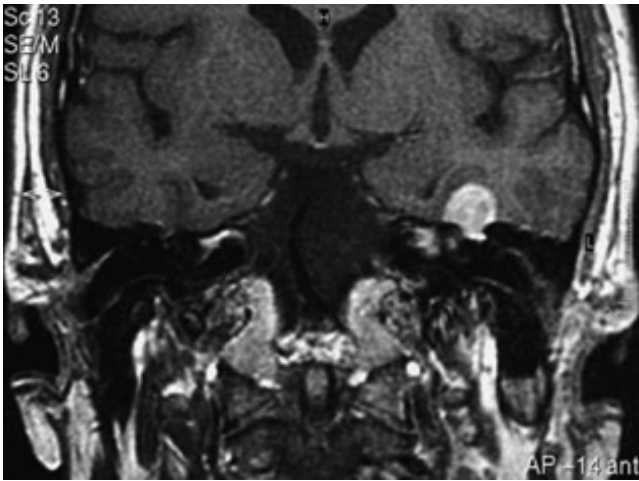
Coronal MRI showing a facial schwannoma arising from the geniculate ganglion and extending through the petrosal foramen into the middle fossa, pushing upwards into the temporal lobe.
